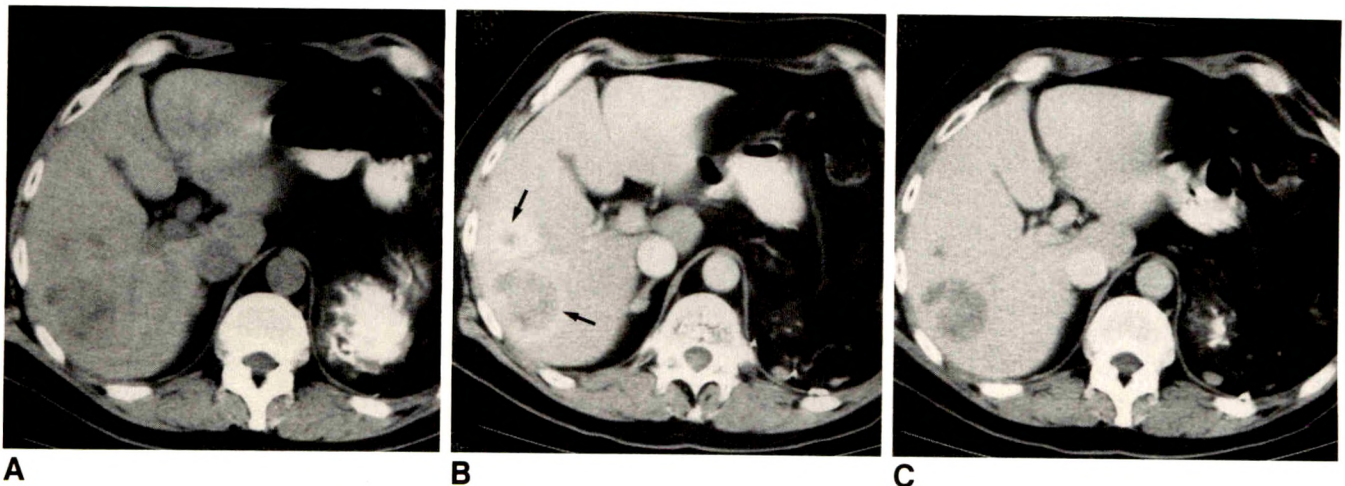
CT scans of patient with liver metastases from renal cell carcinoma.
